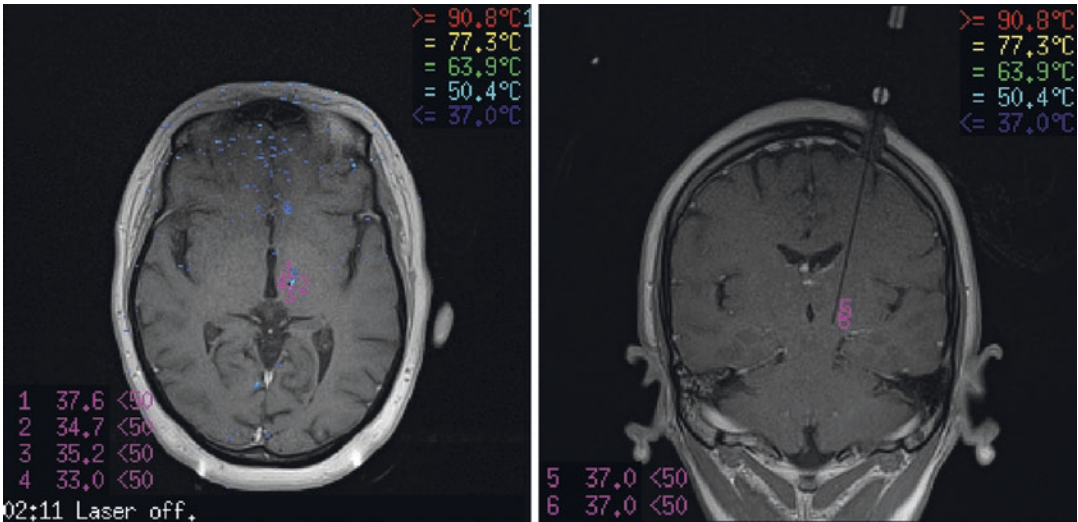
Six critical safety points are chosen for thalamotomy planning on axial and coronal MRI scan
